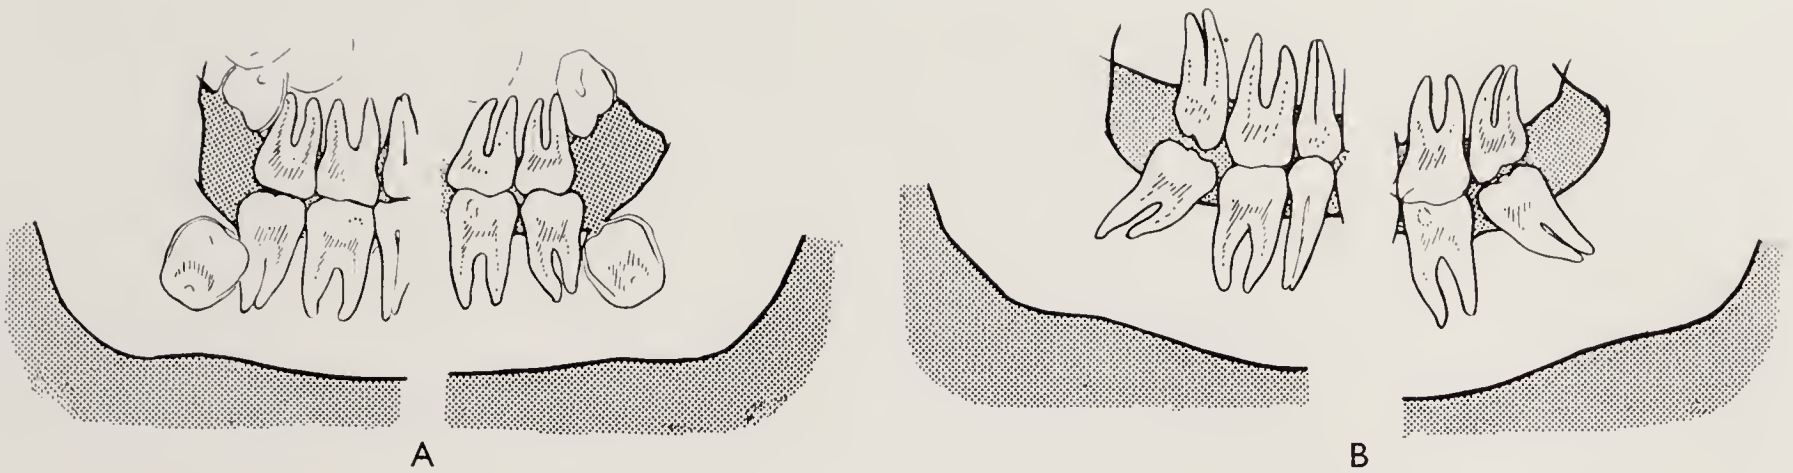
Radiographs taken: A, At 14 years of age, 1 year before removal of $\frac{7}{7}$; B, Two years after extraction.
